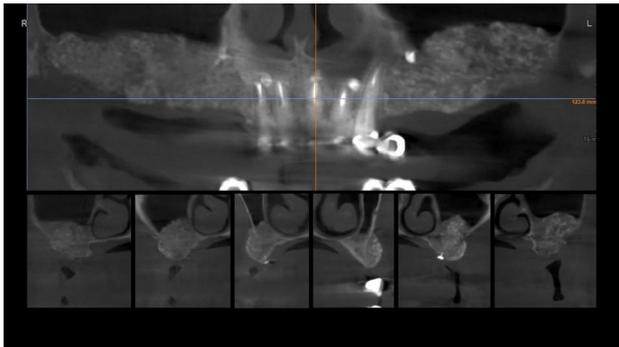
Six months postoperative CBCT scans.
